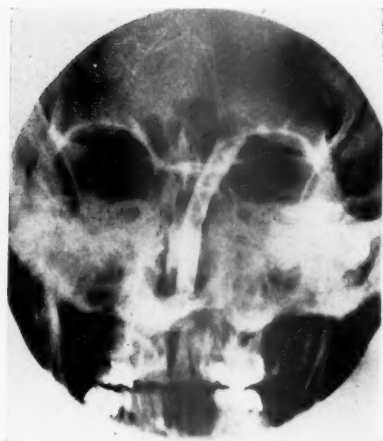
Roentgenogram showing tantalum foil covering a soft rubber catheter in the frontal sinus. A tantalum wire retention suture is seen also.
